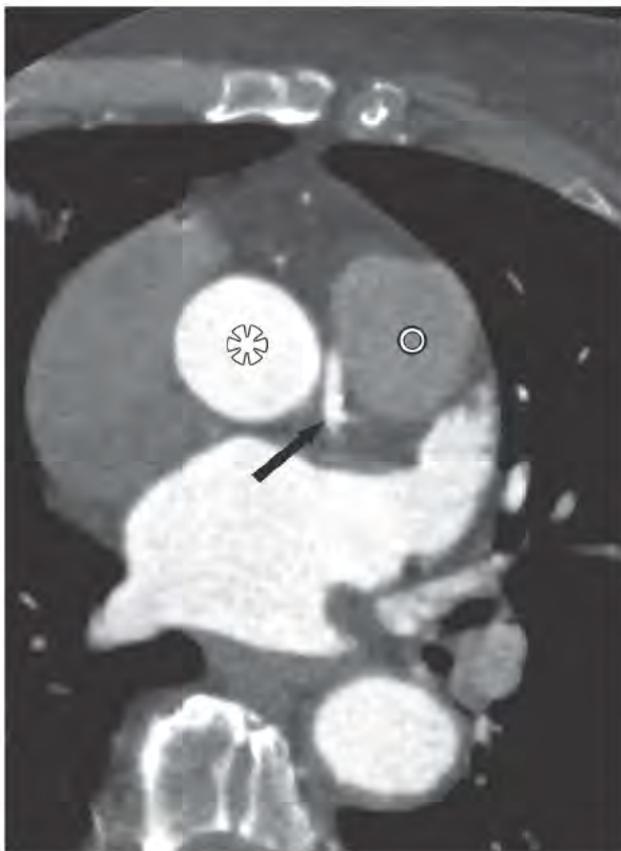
Computed tomography angiography (axial view)
